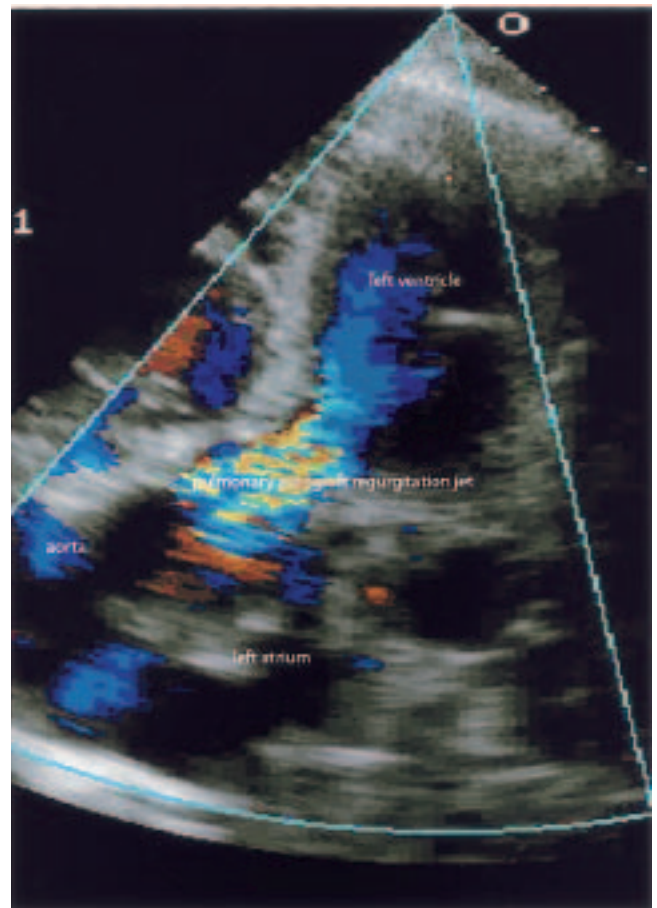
Transthoracic echocardiographic apical five-chamber view showing severe pulmonary autograft regurgitation by color-flow Doppler.
